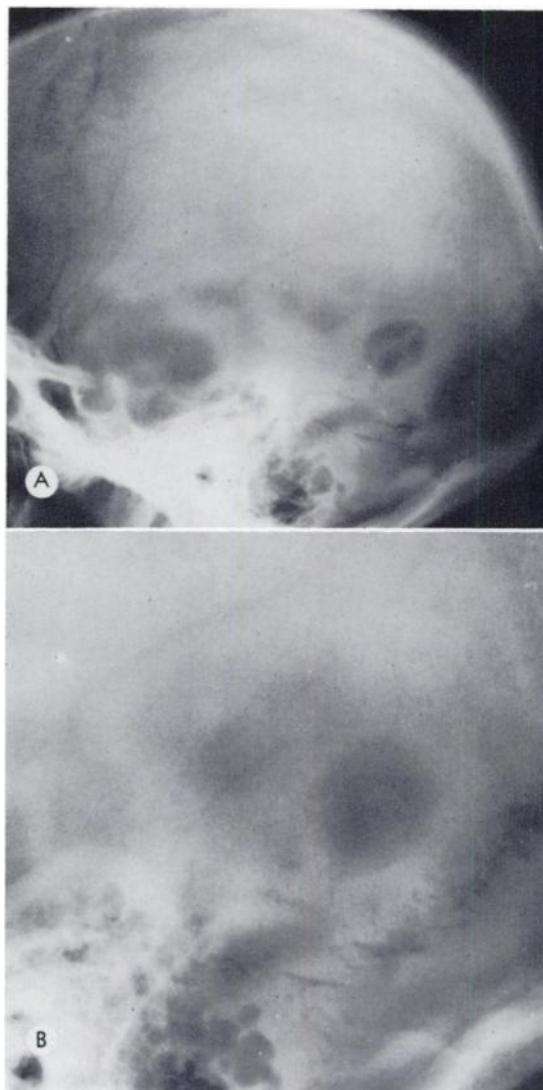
(*A*) Roentgenogram of skull shows well defined radiolucent lesion in parietal bone. (*B*) Central opaque button disappeared in 6 months, but note bevelled edge of lesion.
